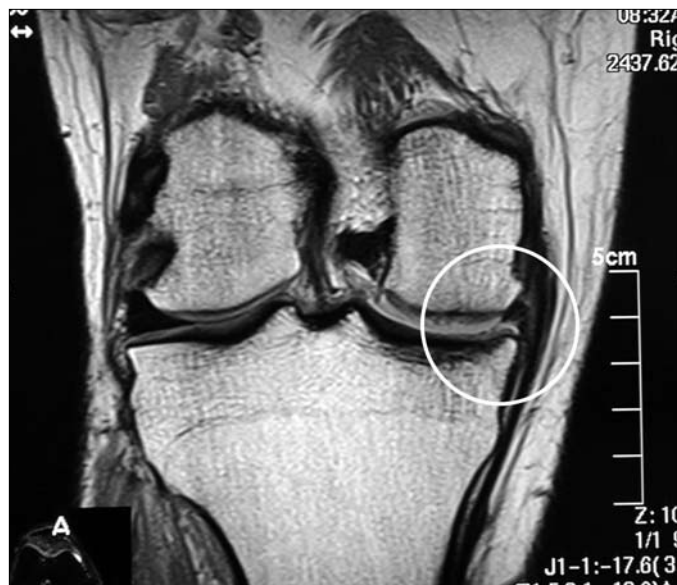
False-positive MRIs of the knee in teenagers. Because significant abnormalities show up in the menisci on MRI in teenagers, when no true injury exists, relying on this modality to make a diagnosis is a scary proposition, especially if surgery is contemplated.
